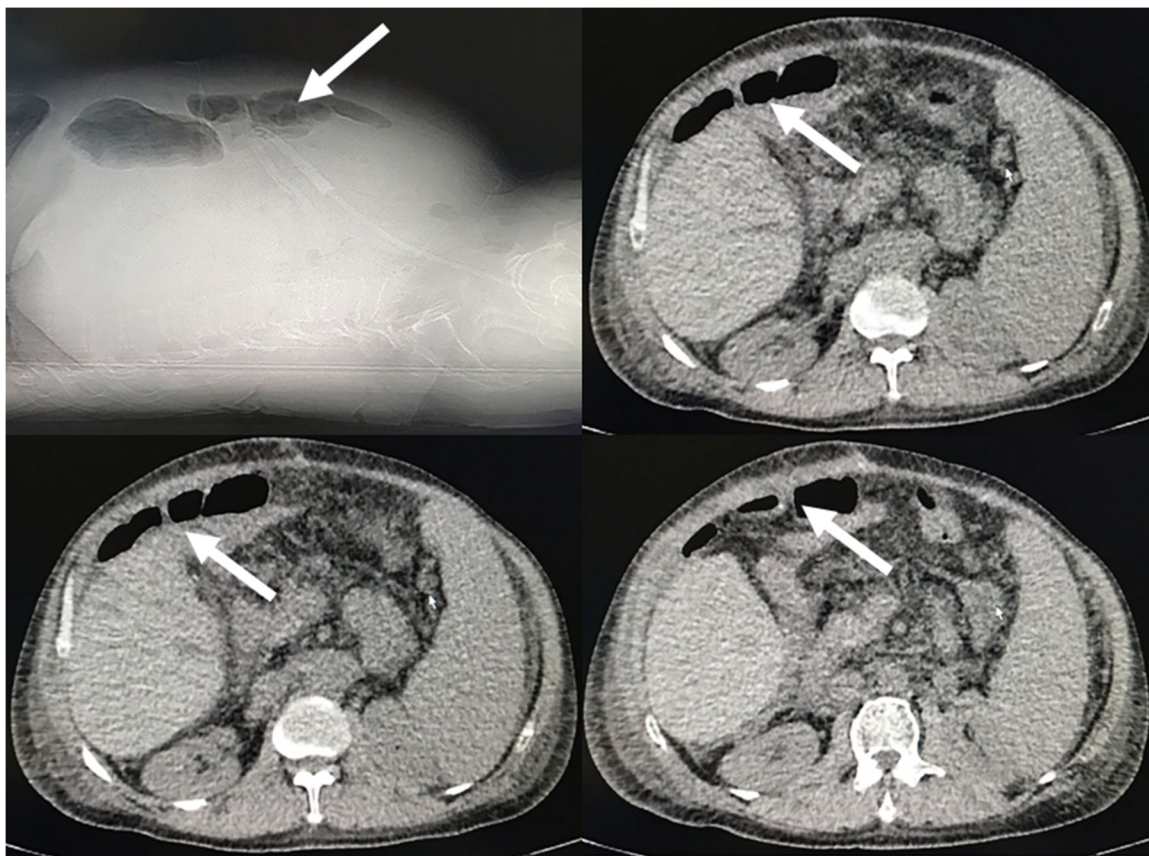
Preoperative non-contrast abdominal computed tomography showing fixed dilated small bowel loop (arrow).
